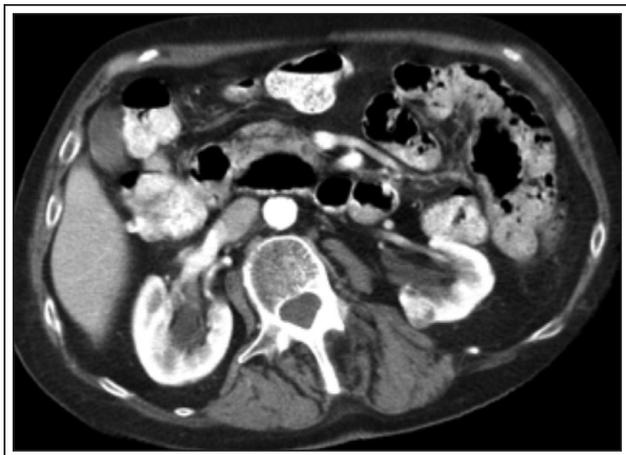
Axial CT, September 2008, showing 1.4 cm L renal mass.
